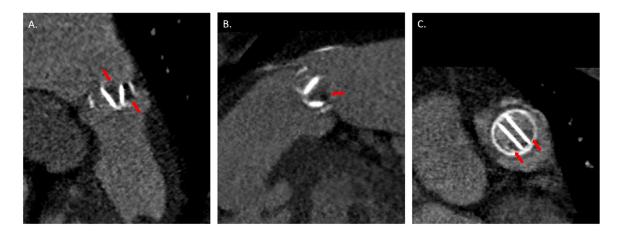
Computed tomographic multiplanar reformats of the mechanical pulmonic valve before thrombolysis. Long axis (A and B) and short axis (C) views demonstrating the mechanical prosthetic pulmonic valve with large thrombus burden (red arrows) in a fixed open position.
